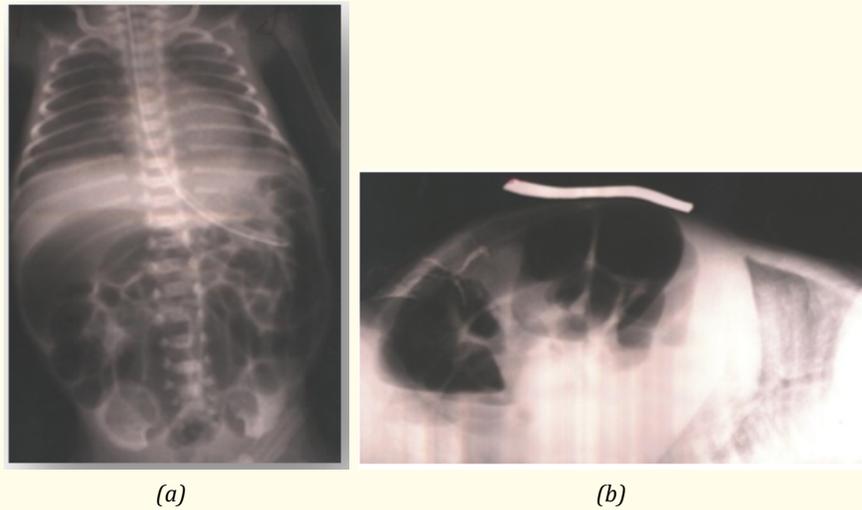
On the chest and abdominal radiographs, in the direct and lateral positions: the distal ileum sharply widened in comparison with the proximal loops of the jejunum (compiled by the author).
